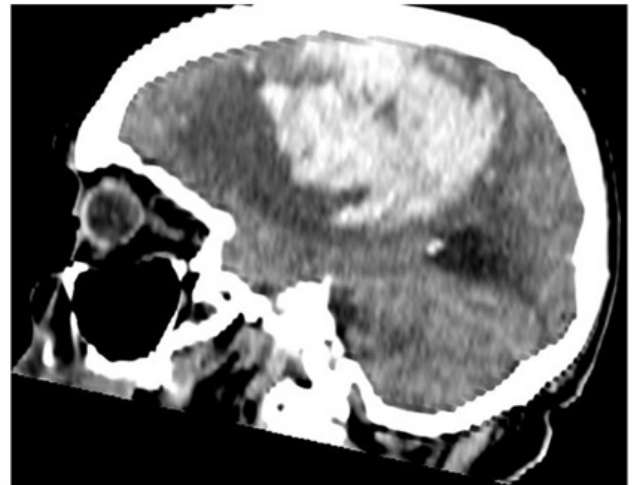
Representative brain computed tomography (sagittal section) image of a patient with lobar hematoma
